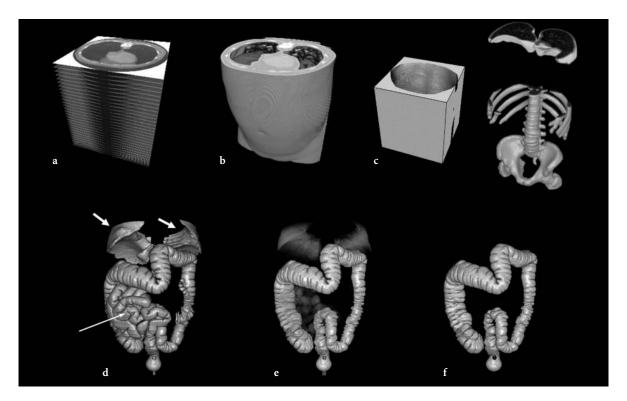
The KGS segmentation process. a Axial CT images from a VC examination. b 3D isotropic volume of the abdomen generated from the CT image in (a). c Extracolonic structures removed in the anatomy-based extraction process. The process first eliminates the region outside the body (*left*), the lung bases (*upper right*), and the osseous structures (*lower right*). d Result of the anatomy-based extraction. This process extracts the entire colon; however, a portion of the lung bases (*thick arrows*) and small bowel (*thin arrow*) remain unremoved. e Segmentation of the colon by use of colon-based analysis. This process identifies the air-filled colonic lumen by use of volume growing. The identified colonic lumen is highlighted, whereas the extracolonic structures are dimmed. f Final segmented colon obtained by intersection of (d) and (e). Note that the extracolonic structures, which are included in (d), are not present in the final segmentation
